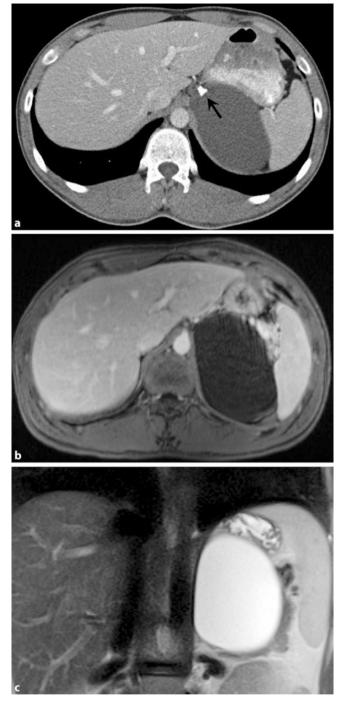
Adrenal cysts. Image of a mass in the area of the left adrenal gland. a In CT the lesion appears hypodense, and b hypointense in fat-supplemented T1W images following administration of contrast agent. c In T2W images it appears noticeably hyperintense in the form of a cyst. Following administration of contrast agent, neither CT nor MR imaging reveals uptake in the thin wall. In CT, detection of localised wall calcification (arrow, a)
